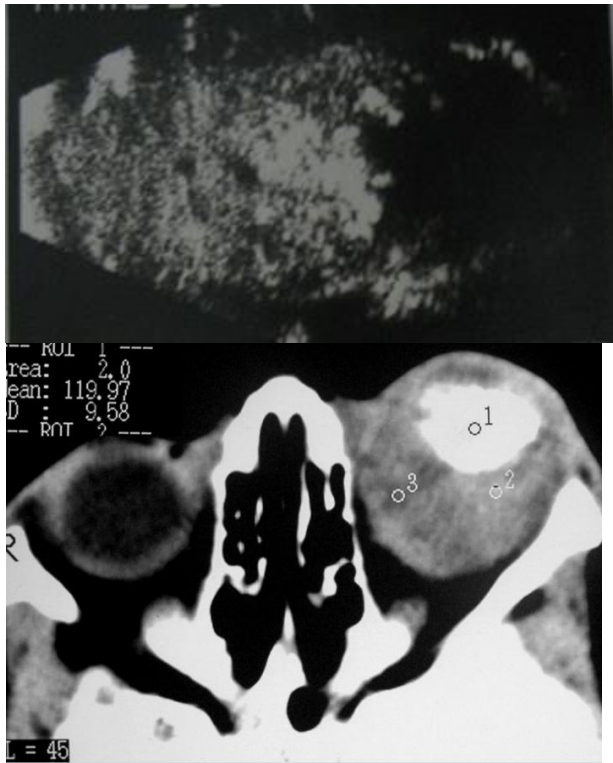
B-scan and CT of orbit showing calcified mass- Retinoblastoma (infiltrative tumour with areas of calcification).
